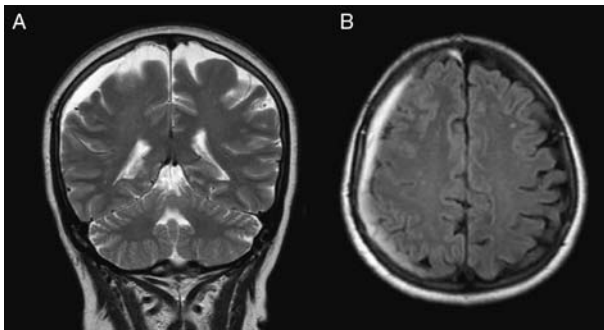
Coronal and axial images of subdural hemorrhage on conventional MRI T2-weighted sequence (A and B).
